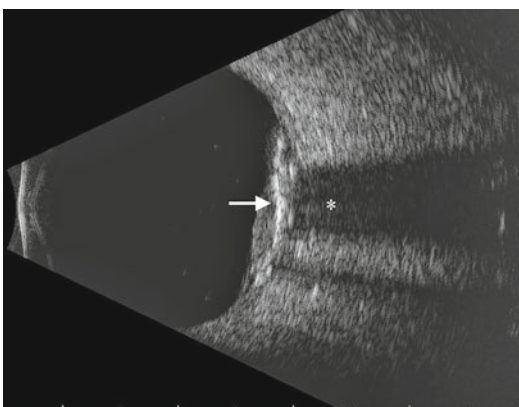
Quantitative ultrasonography (sound attenuation, B-scan). Transverse B-scan shows an irregularly shaped fundus lesion with highly reflective areas (arrow) causing shadowing of the orbital structures (asterisk) (Reproduced with permission from Hayden and Singh [31])
